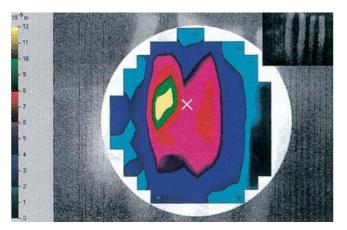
Laser Doppler scanning vibrometry of cartilage palisades in the on-edge position. The arrangement of the cartilage is shown in the black-and-white inset. Where the cartilage strips are slightly apart, the intervening membrane can vibrate at a considerably greater amplitude (yellow). The frequency curve was plotted at the white cursor (see Fig. 2.18).
